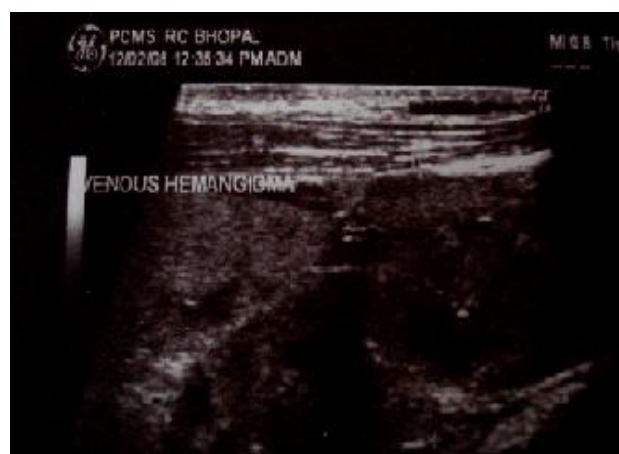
Sonography reveals irregular anechoic spaces with calcification.
